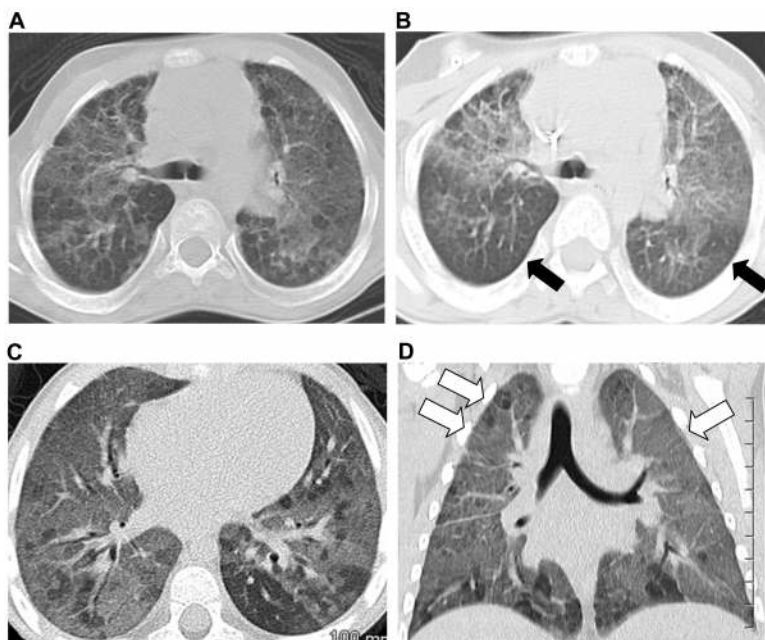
Representative computed tomography scan images from two children with HPS-2 and severe interstitial lung disease. (A) shows severe bilateral ground glass opacities, thickening of interlobular septa and pulmonary fibrosis at the level of the carina for subject 1 at 8 years of age. A computed tomography scan image at the same level shows mild improvement in infiltrates (arrows) at 14 years of age (B). (C) shows extensive bilateral ground glass opacities when subject 4 was 4 years of age. A coronal CT scan image demonstrates diffuse ground glass infiltrates and interstitial reticulations (open arrows) in subject 4 (D).
